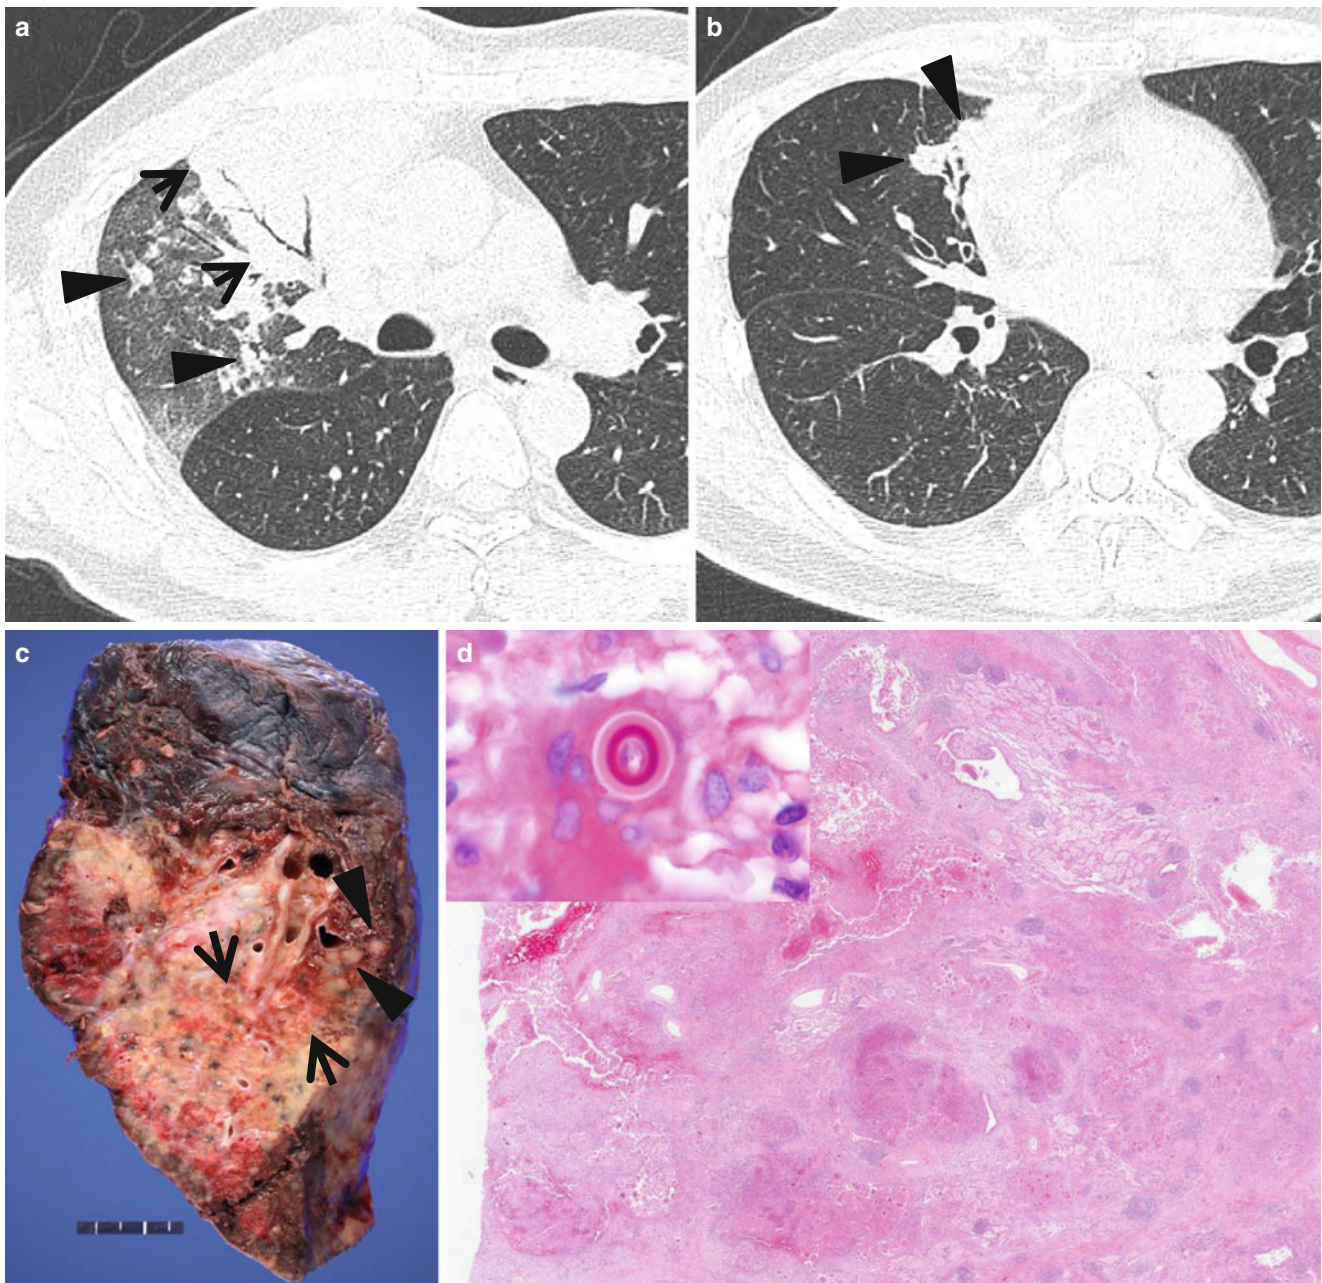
Pulmonary blastomycosis manifesting as morphologic bronchopneumonia in a 45-year-old man. (a) Lung window image of thin-section (1.5-mm section thickness) scan obtained at level of main bronchi shows combination of subsegmental consolidation (*arrows*), acinus-sized small nodules (*arrowheads*), smaller nodules, and ground-glass opacity in right upper lobe. (b) CT scan obtained at level of basal trunk demonstrates nodular clustering (*arrowheads*) in right
